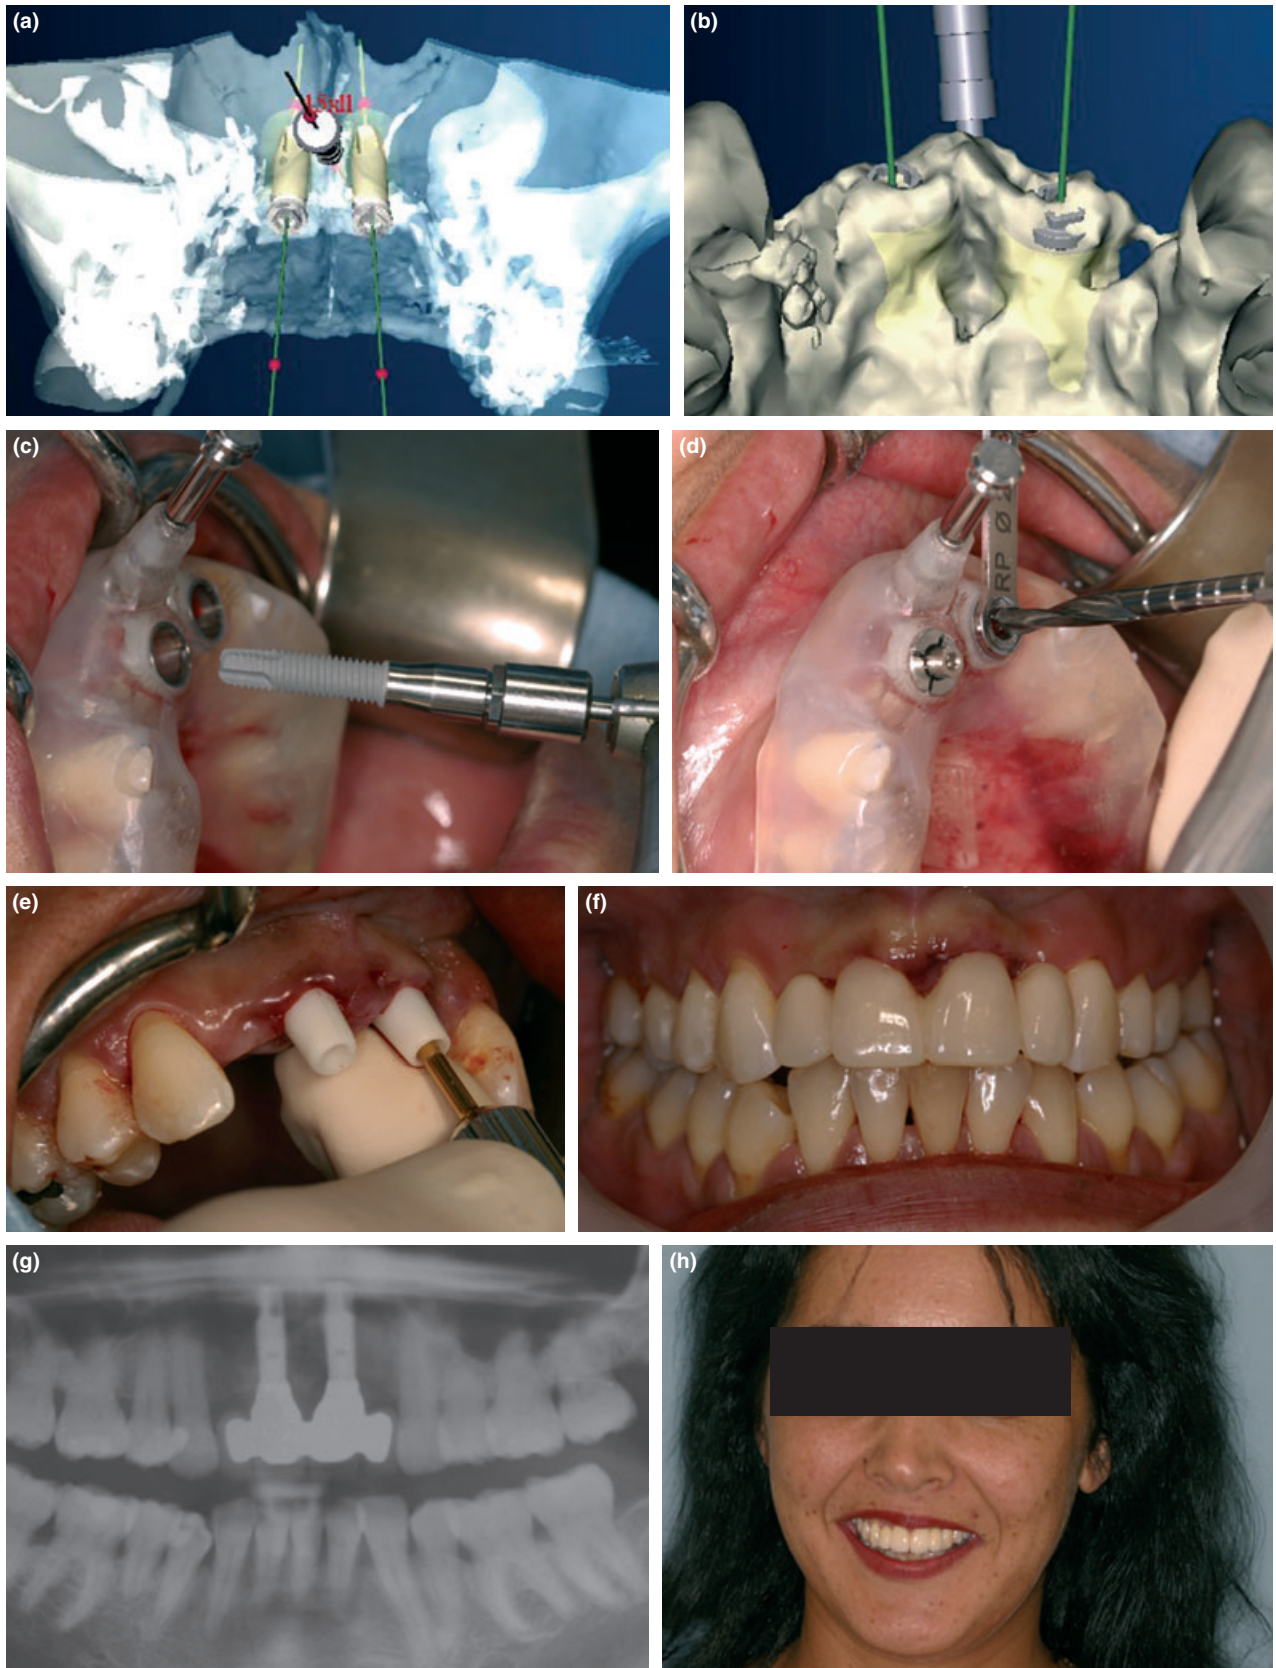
Patient 6. (a) Software planning for implant placement anterior maxilla, labial view. (b) Software planning for implant placement anterior maxilla, palatal view. (c) Implant installation sequence. (d) Instrumentation sequence through anchored surgical template. (e) Surgical template removal and zirconia abutment placement. (f) Placement of provisional acrylic prosthesis, SVT. (g) Panoramic radiograph 2-year follow-up, zirconia abutments and prosthesis. (h) Aesthetic outcome, 2-year postoperative follow-up.
